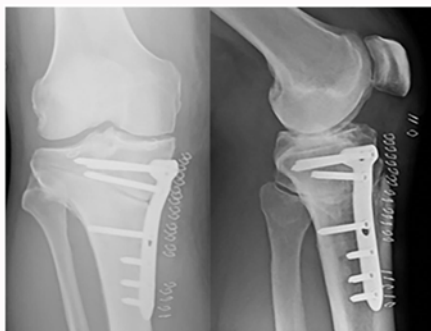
Postoperative anteroposterior and lateral radiographs of the knee showing successful valgus and slope re-correction.
